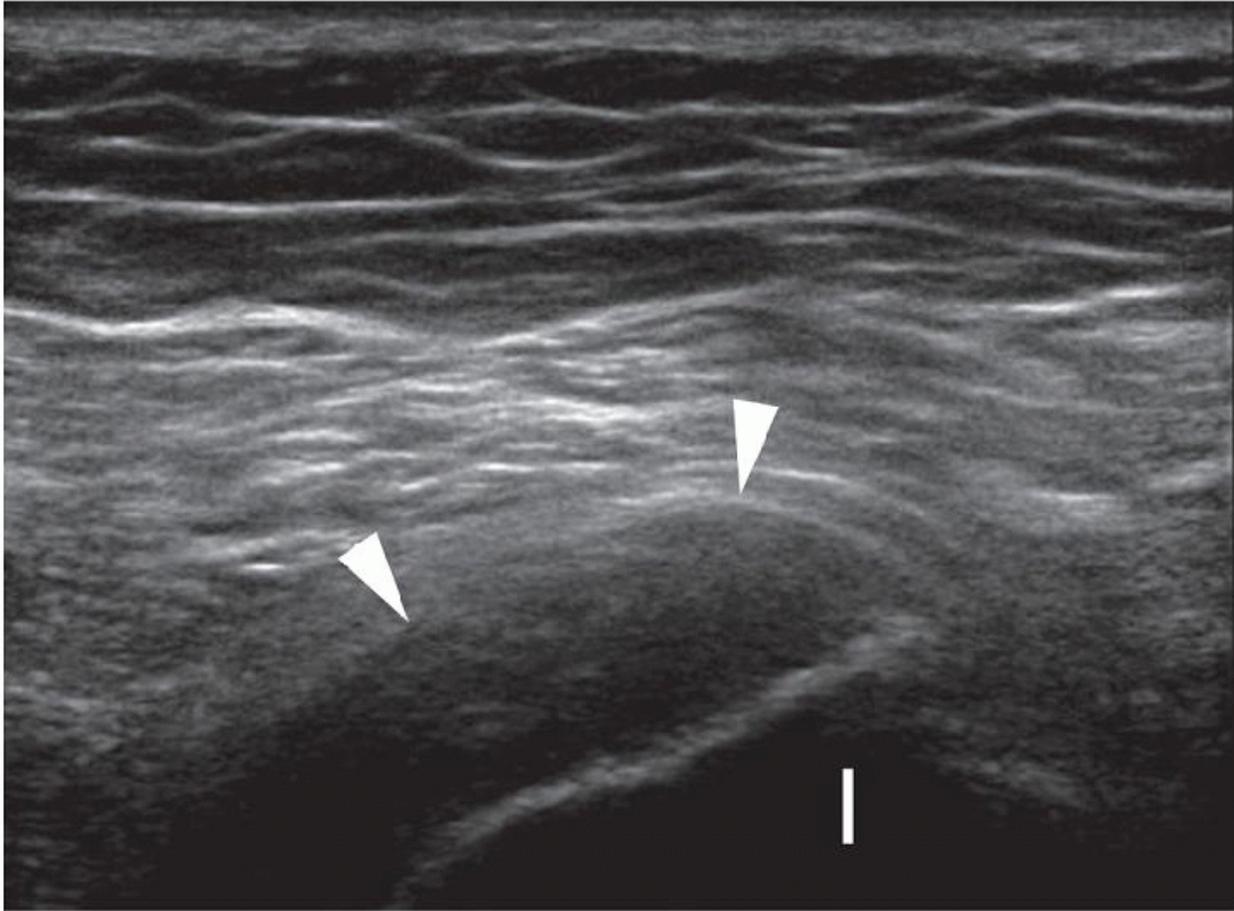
Overuse hamstring tendinopathy. Longitudinal sonogram shows hypoechoic thickened hamstring origin tendons (arrowheads) and adjacent ischial tuberosity (I).
